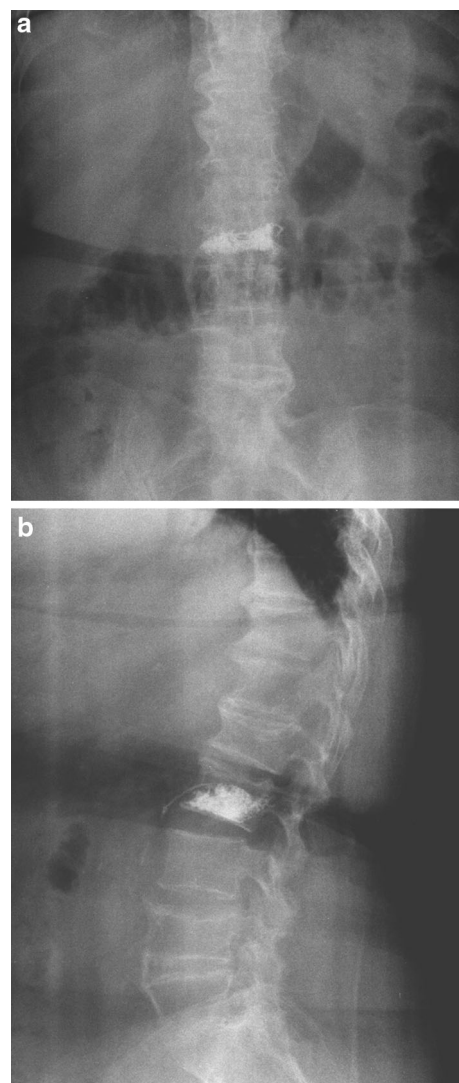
a, b Postoperative 1 year follow-up anteroposterior and lateral X-ray images
